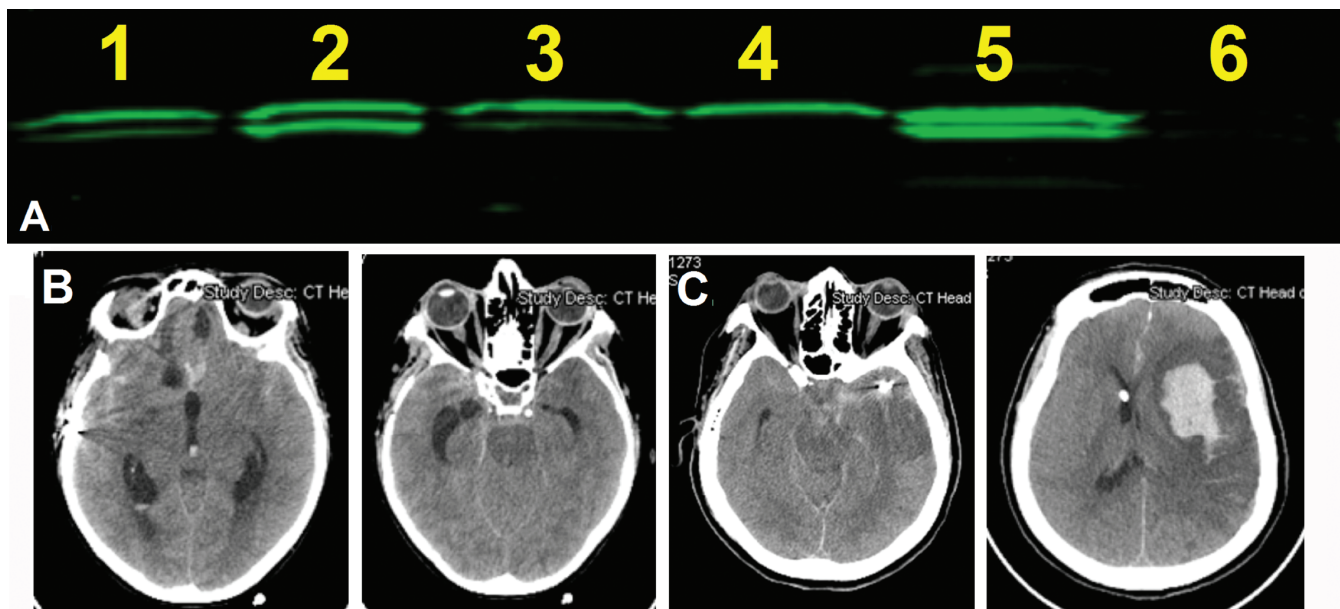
A: Representative Western blot of HMGB1 in CSF samples collected from patients with aneurysmal SAH (lanes 1–5) and a control patient with NPH (lane 6). Blots were imaged using a Li-Cor Odyssey near-infrared imaging system. Patients with SAH consistently presented with an ~ 25 kD band corresponding to HMGB1, whereas patients with NPH did not show a clear band. B: Noncontrast axial CT scans of a 45-year-old woman with a Hunt and Hess grade of III and a Fisher grade of 4. The patient was sleepy and confused following a ruptured left posterior communicating artery aneurysm. The patient's HMGB1 sample is depicted in lane 2 (A). C: Noncontrast axial CT scans of a 77-year-old woman with a Hunt and Hess grade of IV and a Fisher grade of 4. The patient was stuporous with significant right hemiparesis following a ruptured left middle cerebral aneurysm. The patient's HMGB1 sample is depicted in lane 5 (A).
